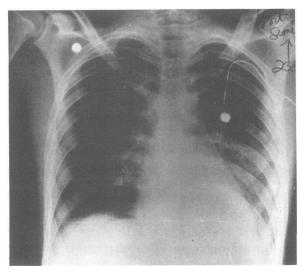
Chest radiograph on eighth hospital day. Alveolar infiltrate left lower lobe. Minimal infiltrate right lower lobe. Vital capacity 1.55 liters; alveolar volume 2.89 liters; single breath diffusing capacity for carbon monoxide (DLCO) 10 ml per minute per mm of mercury.
